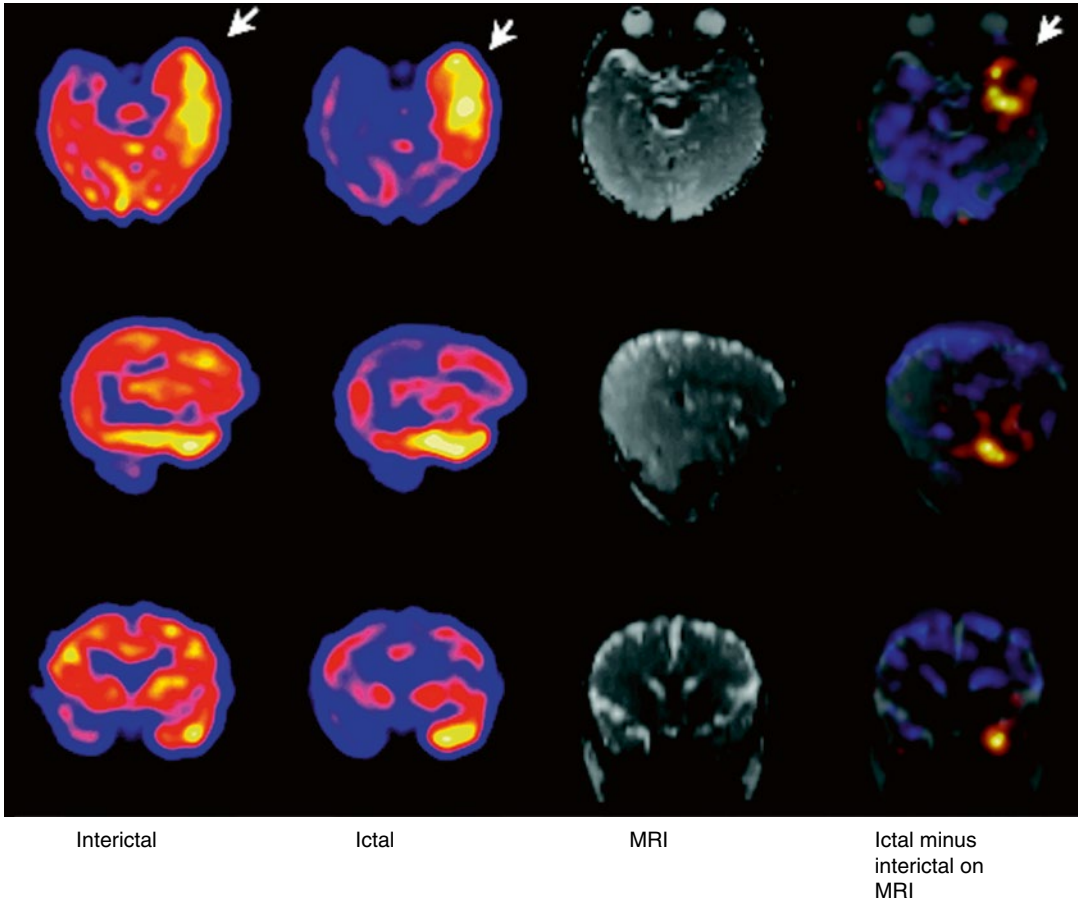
Young child with infantile spasms. The interictal ^{99m}Tc -ECD SPECT reveals relatively increased perfusion in the left temporal lobe, probably indicating activity in this region. The ictal SPECT shows a dramatic increase
